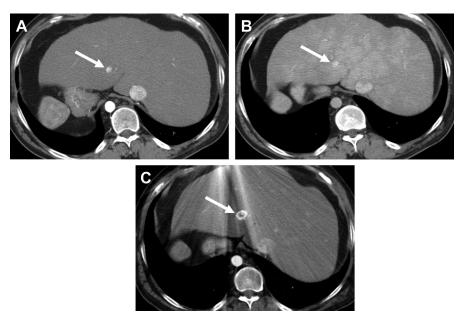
A 40-year-old man with history of situs inversus and prior Fontan procedure. Axial contrast-enhanced CT images show gradual increase in size of FNH-like nodules over a period of 5 years. Note the homogeneous enhancement and central scar of the dominant lesion (*arrow*) typical of FNH-like nodule.
